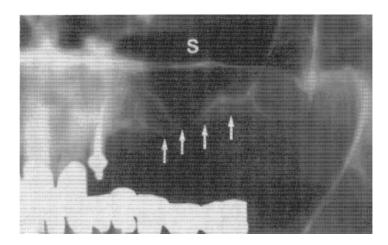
(a). Radiograph of a 69-year old woman shows that the amount of bone in the area of left maxillary sinus (S) is insufficient (arrows) to support dental implants. A sinus lift operation using a mixture of bioactive glass granules and autologous bone chips was made to achieve more bone on the floor of the maxillary sinus. Implants were inserted eight months after the sinus lift operation.
